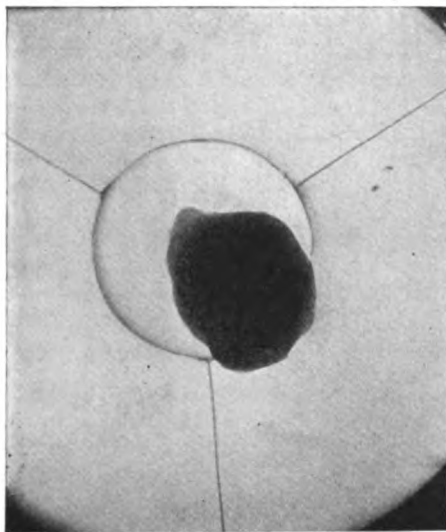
Radiograph of prostatic calculus after removal (one-half natural size). Radiating cellular diaphragm employed.
